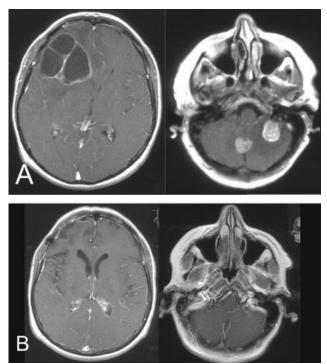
A 63-year-old woman with ovarian carcinoma developed a severe bifrontal headache rather suddenly. A year before, she had received aggressive resection of her primary disease, and had completed 2 months prior to the onset of symptoms, 6 cycles of intravenous carboplatin/paclitaxel before symptom emergence. (A) An axial T1 gadolinium-enhanced magnetic resonance imaging (MRI) scan displays 3 lesions: a right frontal ring-enhancing cystic lesion surrounded by vasogenic edema and producing a significant mass effect, and 2 homogeneously enhancing posterior fossa tumors producing 4th ventricular compression. The right frontal tumor was resected, and the patient was exposed to carboplatin tridrug blood-brain barrier disruption treatment in the vertebrobasilar distribution. The patient presented with a complete response (CR) after 12 cycles of treatment, and still maintains this CR as shown on a follow-up MRI scan > 1 year after treatment discontinuation (B).
